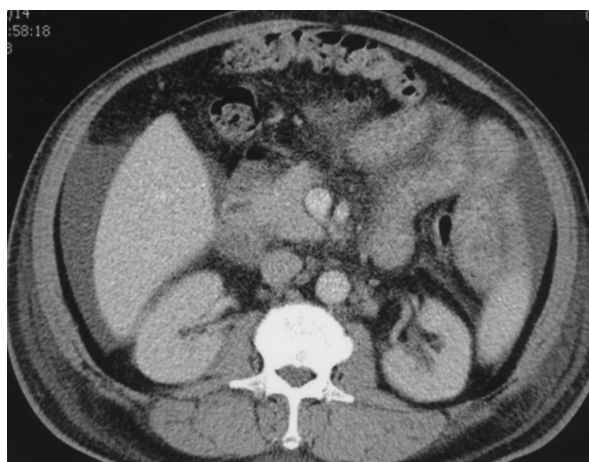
Abdominal computed tomography shows mild ascites and congestive mesenterium (case 1)
